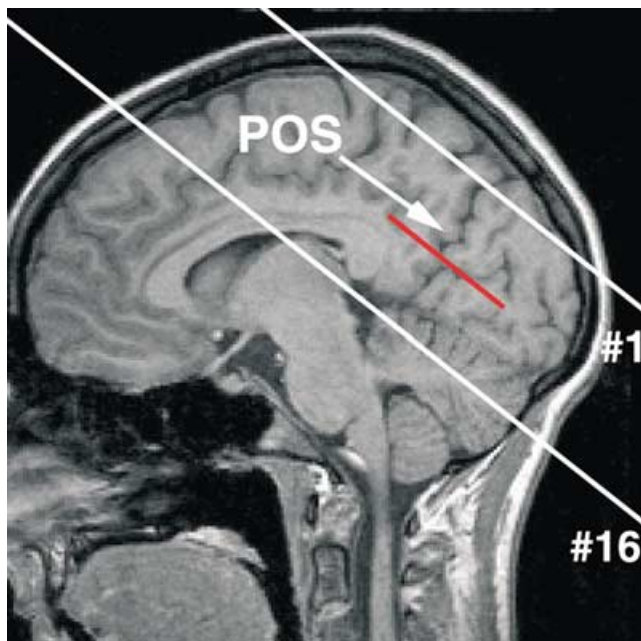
Sagittal T1-weighted anatomic MR image depicting the orientation of the volume (16 sections) selected for functional mapping of the visual system including areas adjacent to the POS. The red bar represents the reconstructed plane used for dividing the POS into an inferior and superior portion (for details see text).
